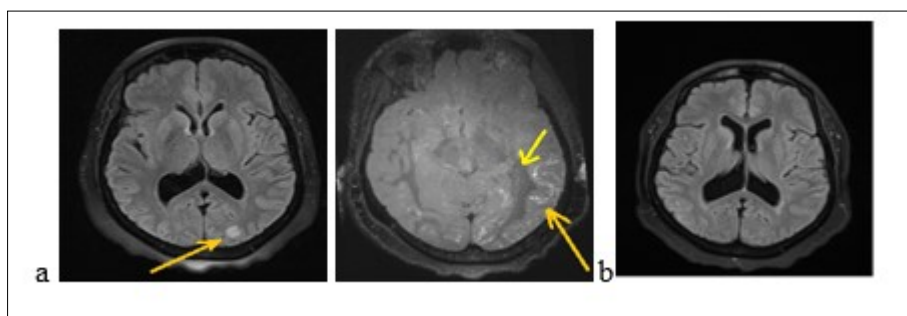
Cerebral MRI showing a left occipital edema and a diffuse contrast enhancement of the leptomeninges (a) with complete decrease of the lesions after treatment (b)
